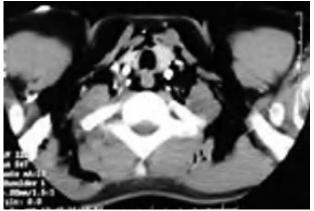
Computed tomography chest scan of case 5. The patient had a traumatic injury with subcutaneous cervical emphysema without subsequent progression and underwent conservative treatment. The injury involved the thoracic trachea and bronchi without associated pneumothorax.
